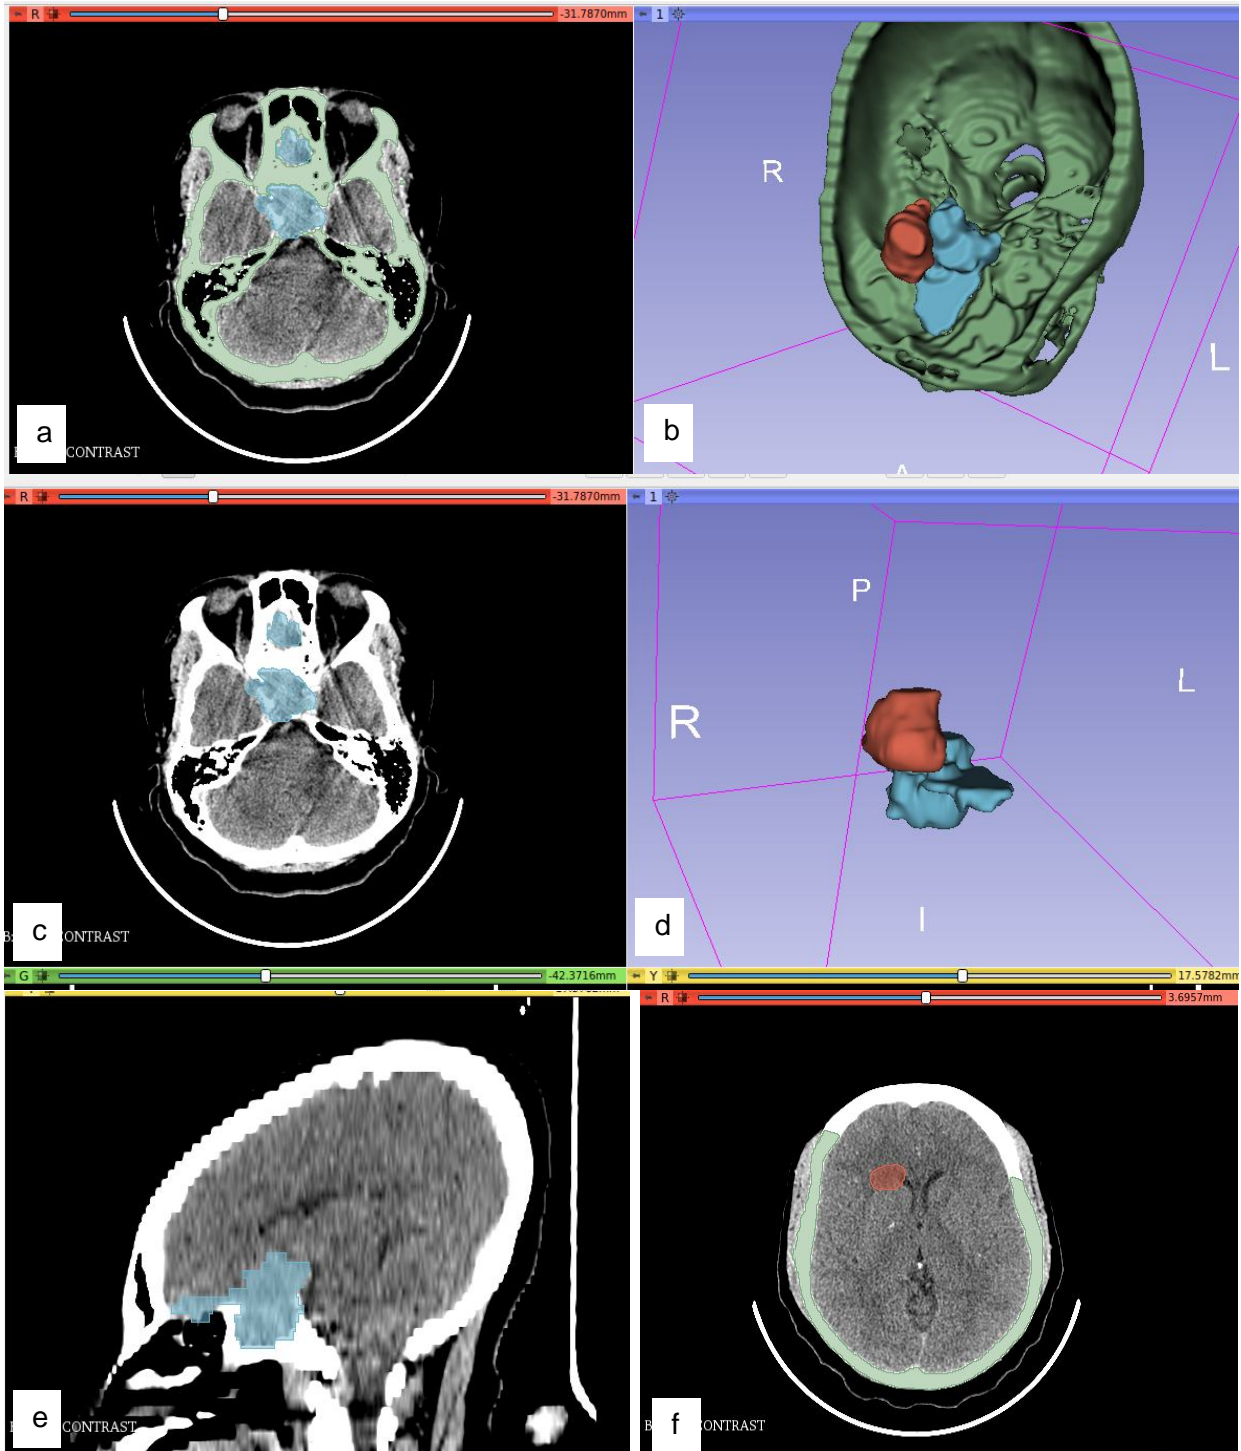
Case 3 a-f: Axial and sagittal Images showing irregularly shaped solid mass (blue) with calcifications arising from the sella with an adjacent cystic component (brown) extending into the suprasellar space (a, c & e) and into the right frontal lobe base (f) which was not so apparent on the CT stacks. Segmented and 3D volume rendered images of the mass and skull (b) and mass separately (d).
